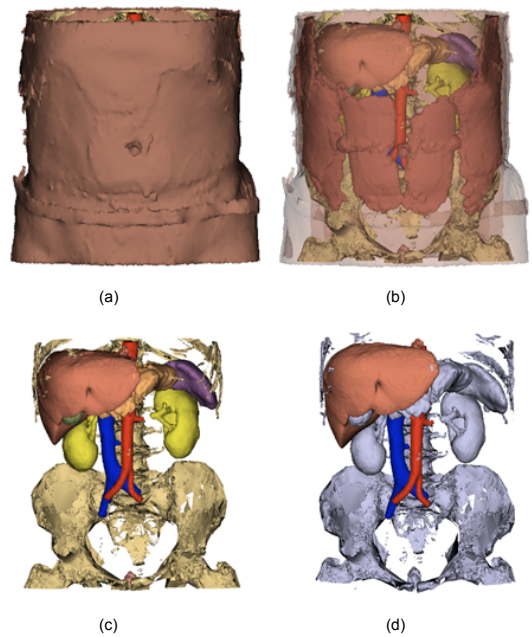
Sample views of 3DSlicer showing different representations of a man abdominal model extracted from a CT scan. a) This image shows the model of the skin. b) The software allows to put the skin in transparency to visualise the internal structures. c) Representation of the internal structures with a color labeling code. d) It is also possible to highlight target structures (vein, aorta and liver).
